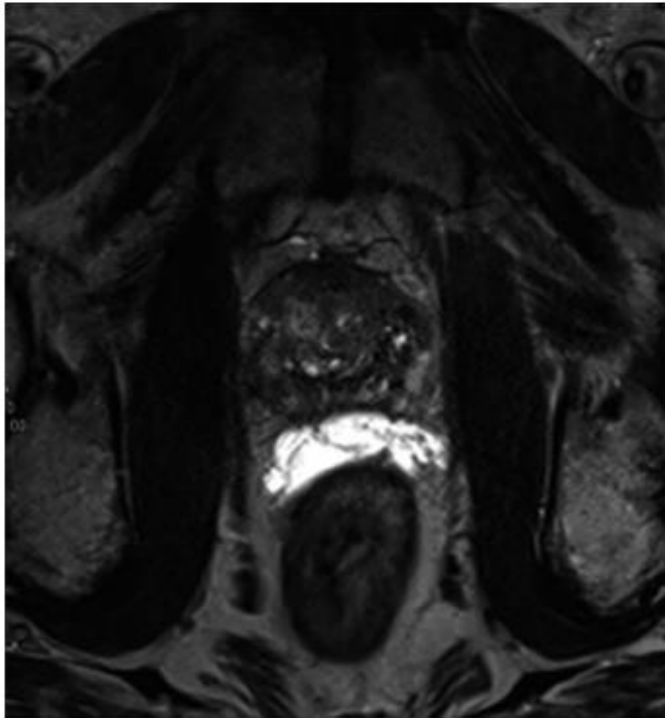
MRI image of SpaceOAR in situ. SpaceOAR appears bright on a T2-weighted sequence. Note the separation between the posterior prostate and anterior rectal wall.
